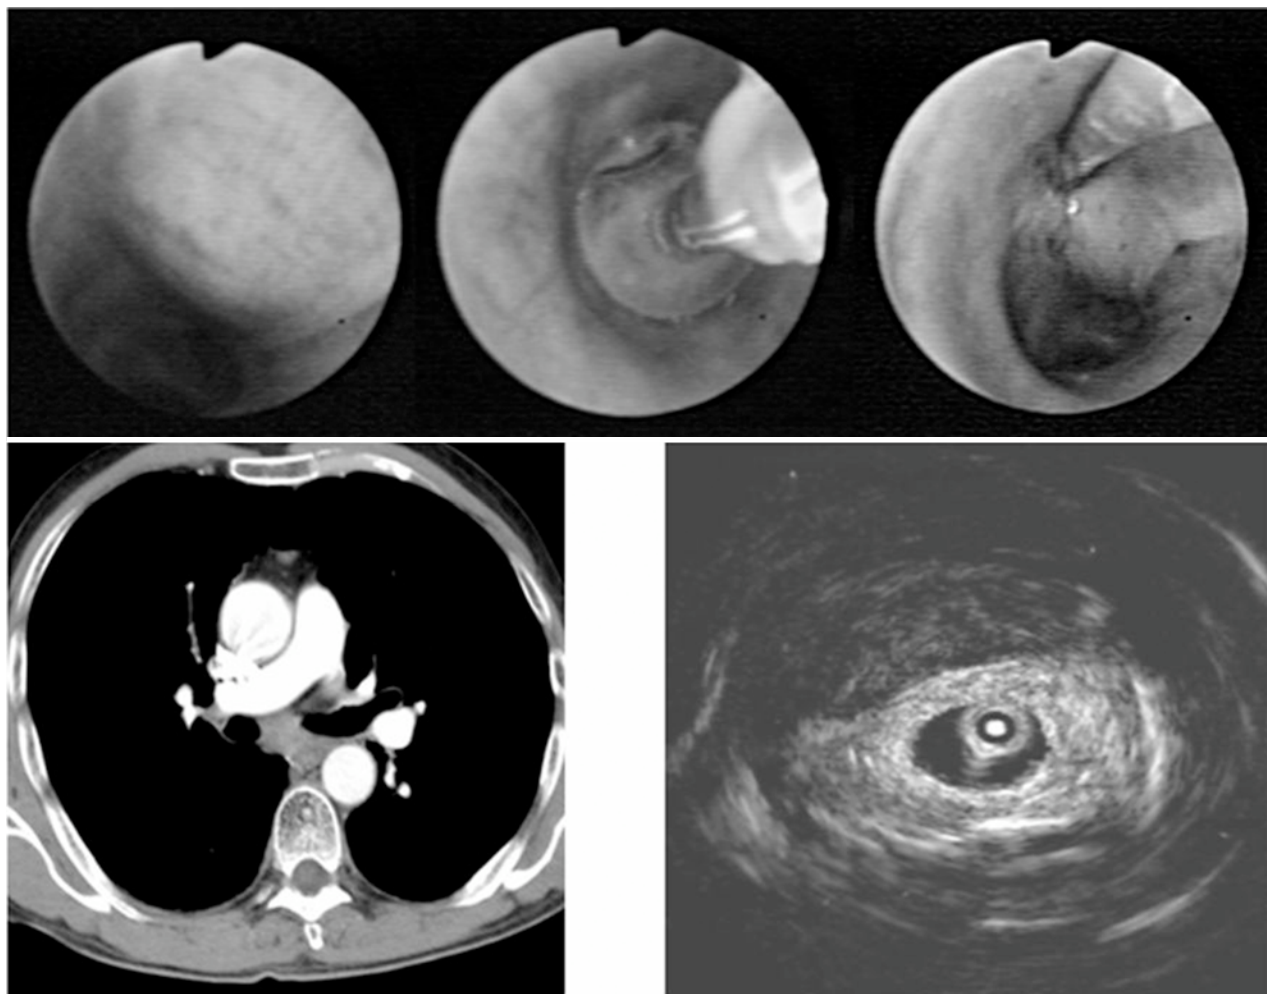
Endoscopy (patient #2) (above): Impression of the left main bronchus due to a mediastinal mass (left). Placing of the EBUS probe (center) with the water-filled balloon catheter, biopsy extraction (right). Axial CT section on the lower left and EBUS on the lower right showing the paratracheal tumor, one pathological lymph node
